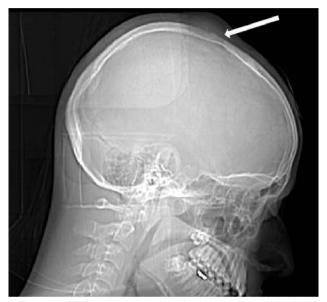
CT Scanogram.III defined lytic lesion (arrow) in skull vault with soft tissue component.
